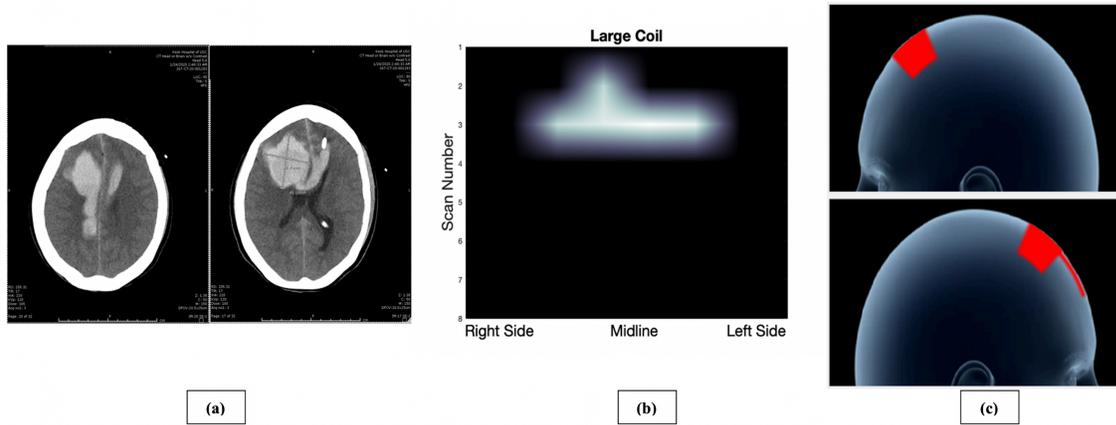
a) CT imaging showing bilateral ICH, right greater than left b) Two-dimensional data gathered from ECD sensor scanning. c) Three-dimensional projections of the lesion. The lesion crosses the midline, so two images are provided with left (top) and right (bottom) profiles.
